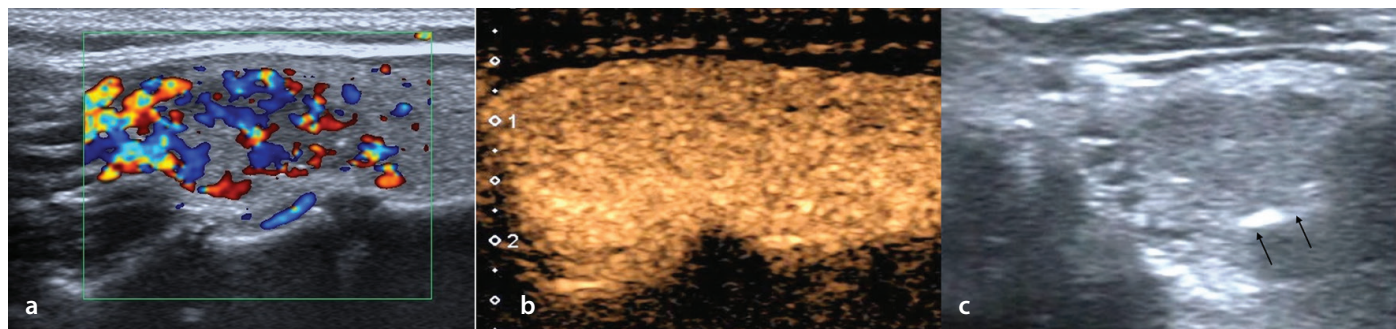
Images in a 64-year-old female patient with a solitary right-sided thyroid nodule classified with conventional ultrasound (US) as category TR4a and classified as Bethesda II following cytopathologic examination. Repeat fine-needle aspiration biopsy (FNAB) was performed 2 years later, showing Bethesda II again. (a) Longitudinal view of the right thyroid lobe displays a hypo-echogenic, well-defined solid nodule. (b) Longitudinal contrast-enhanced US image shows the nodule has homogeneous iso-enhancement. (c) Transverse views show where the regular FNAB was performed (black arrows).
